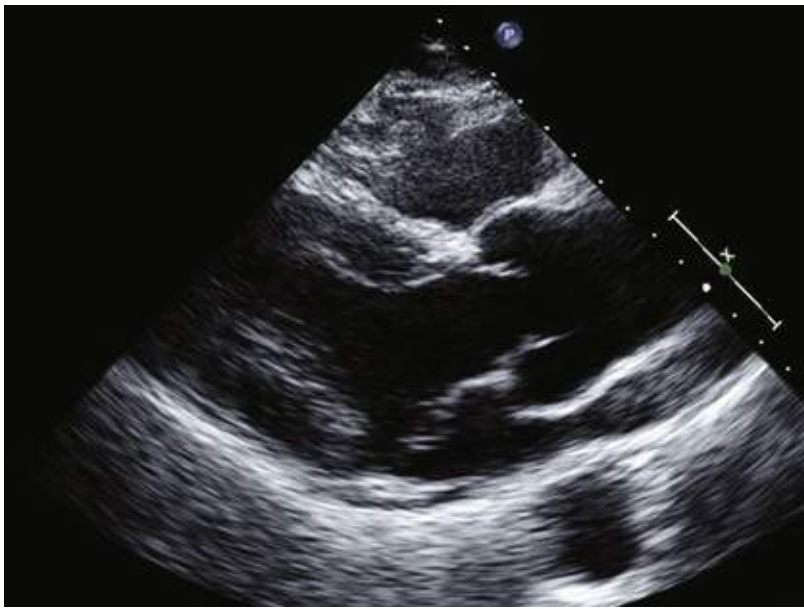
Transthoracic echocardiogram of a dilated aortic root in a patient with Marfan syndrome. The dilation is most pronounced in the sinuses of Valsalva, and the aorta narrows above the sinotubular junction.
